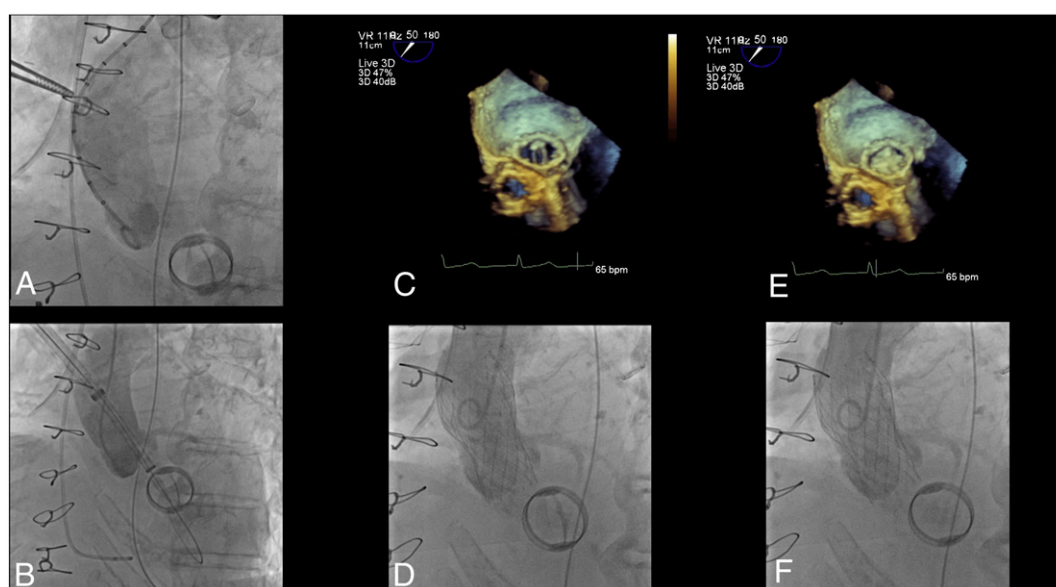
Basal ascending aorta aortography to measure the distance between the aortic annulus and the selected entry site in the ascending aorta, and to obtain a coaxial trajectory between entry site and annulus (A). Evolut 23 mm bio-prosthesis retrograde implantation. Fully expanded Evolut prosthesis across the native aortic valve, aortogram demonstrates good opacification of the left main and anterior descending artery, no evidence of aortic regurgitation and no interference neither distortion of the CoreValve nitinol tube nor malfunction of the bi-leaflet mechanical valve with full leaflet opening and closure during diastole and systole evaluated by echocardiography (C, E) and fluoroscopy (D, F).
